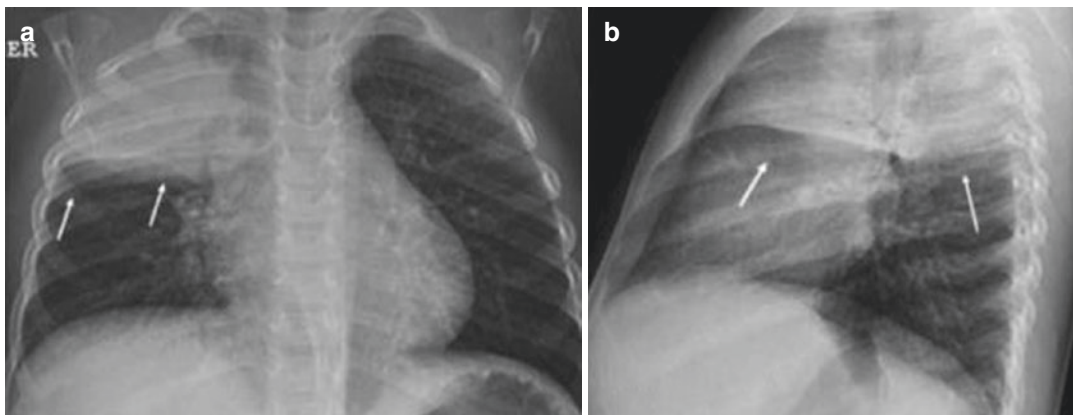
Lobar pneumonia in a 14-month-old infant with a cough and fever. Chest x-rays in the anteroposterior (a) and lateral (b) views show pneumonic consolidation
